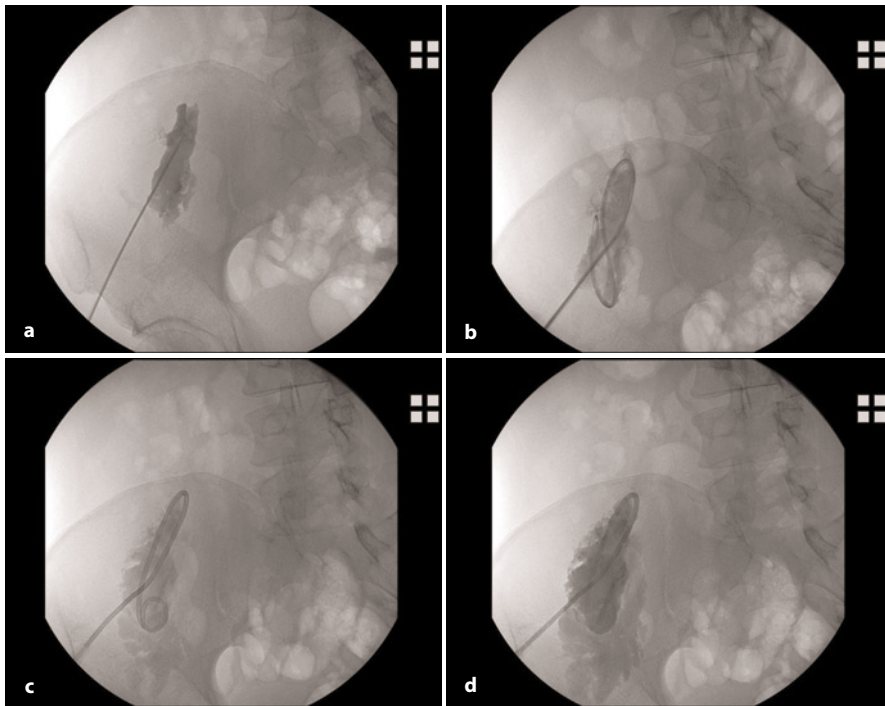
Patient (A). Percutaneous abscess drainage (PAD) is placed in deep pelvic abscess with Seldinger Technique under ultrasonographic and Fluoroscopic guidance. After initial abscess drainage, abscessogram was performed to evaluate enteric communication and no signs were found
